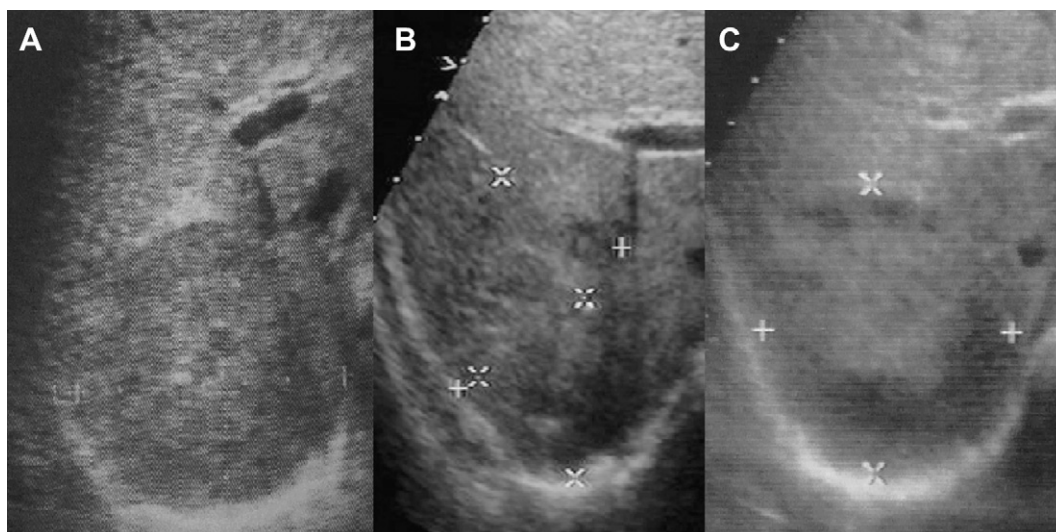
Liver hematoma, case 8: An ill-defined lesion with internal echoes changes in the ultrasonic appearance on (A) the first day, (B) the second day, and (C) the seventh day during admission.
